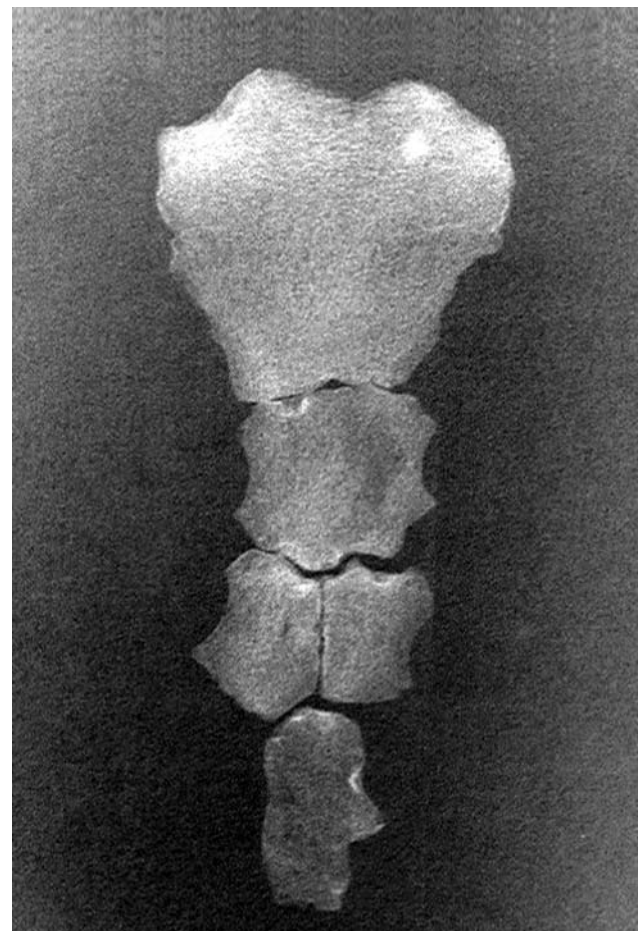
Radiograph of CR 16.1 sternum.
